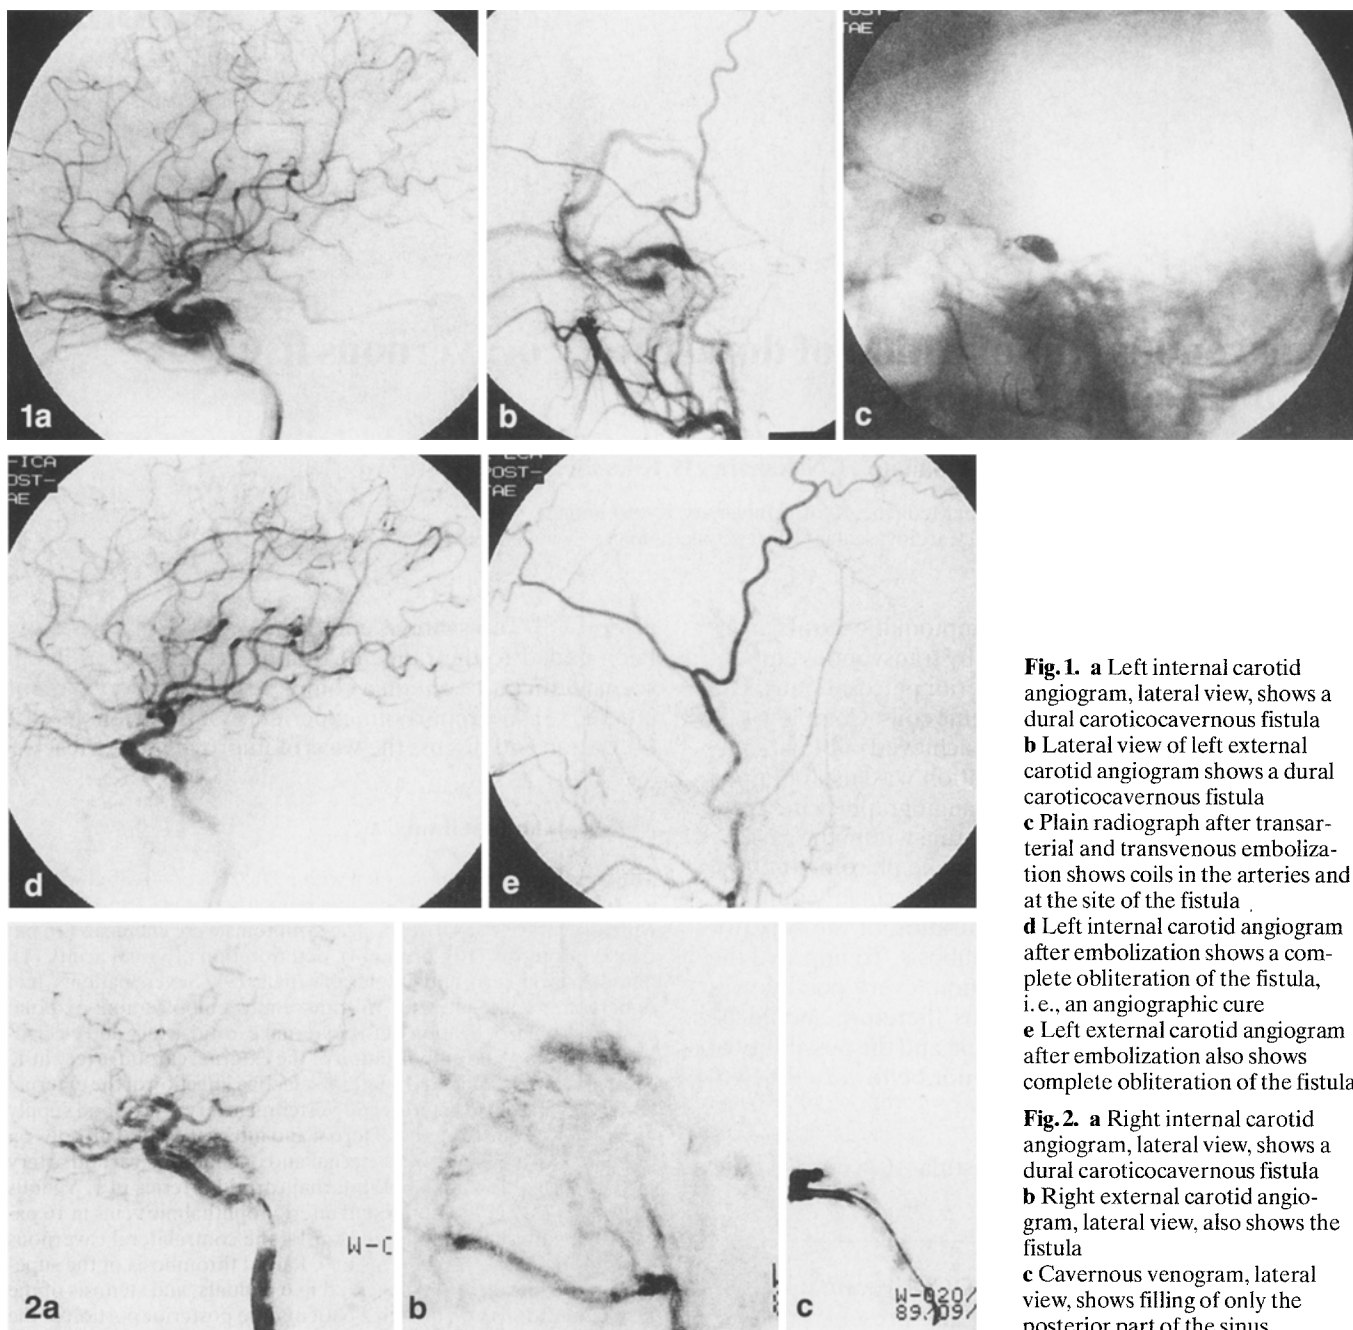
a Left internal carotid angiogram, lateral view, shows a dural carotidocavernous fistula b Lateral view of left external carotid angiogram shows a dural carotidocavernous fistula c Plain radiograph after transarterial and transvenous embolization shows coils in the arteries and at the site of the fistula d Left internal carotid angiogram after embolization shows a complete obliteration of the fistula, i. e., an angiographic cure e Left external carotid angiogram after embolization also shows complete obliteration of the fistula
